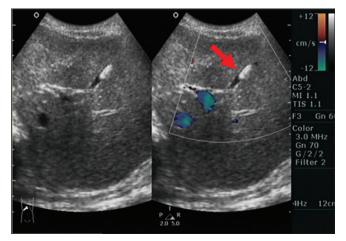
The Doppler ultrasound image showed no internal blood flow in the lesion (arrow)
